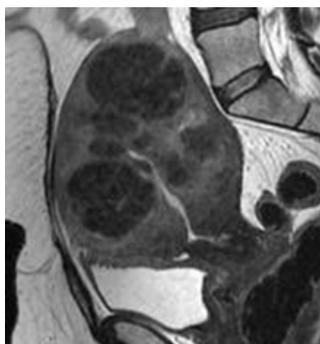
MRI showing multiple fibroids
